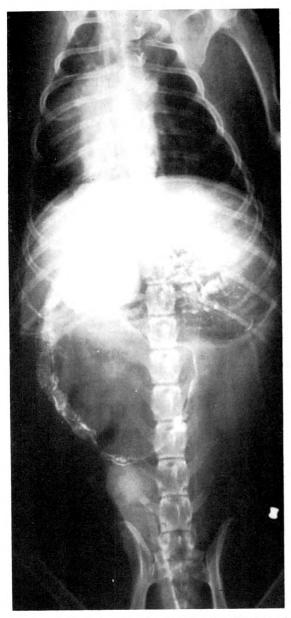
Roentgenogram showing the distribution of 10 grams of micronized iron admixed with 200 cc. of corn syrup before a magnetic field is applied.
